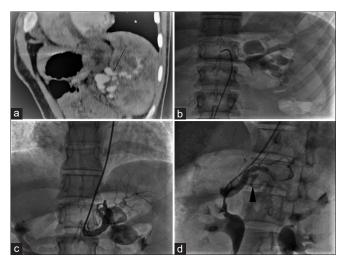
(a) CT sagittal oblique section showing splenic artery aneurysms and splenomegaly, (b) Splenic artery angiogram in AP view using Cobra catheter showing multiple splenic artery aneurysms, (c) Splenic artery angiogram in shallow LAO view; the artery cannulated from the right axillary artery. The arrow points to branches to the spleen from an accessory branch. Multiple aneurysms in the main splenic artery are seen, (d) Splenic artery angiogram post 5/6 ADO-II placement (arrow). Arrowhead points to pancreatic branches from the splenic artery, proximal to the device. CT: Computerized tomography, AP: Anteroposterior, LAO: Left anterior oblique, ADO-II: Amplatzer Duct Occluder-II
